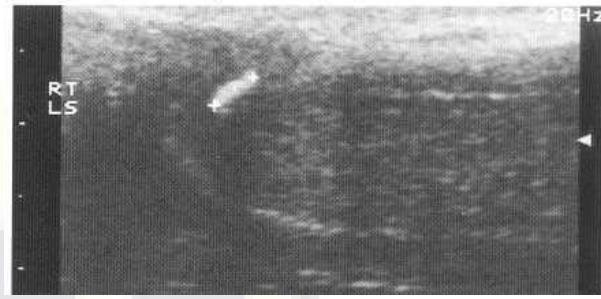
Longitudinal ultrasound of a penis in Peyronie's disease showing a small calcified echogenic plaque with distal acoustic shadowing.
